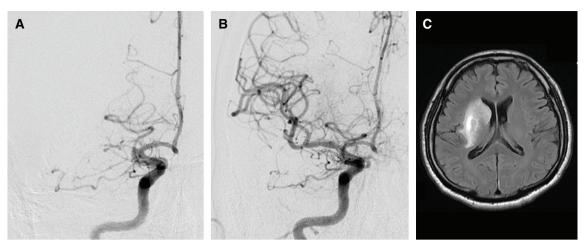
Case 1: (A and B) Frontal images of right internal carotid angiography (A: before thrombectomy and B: after thrombectomy) and (C) FLAIR image of head MRI on the day after thrombectomy. FLAIR: fluid-attenuated inversion recovery; MRI: magnetic resonance imaging
